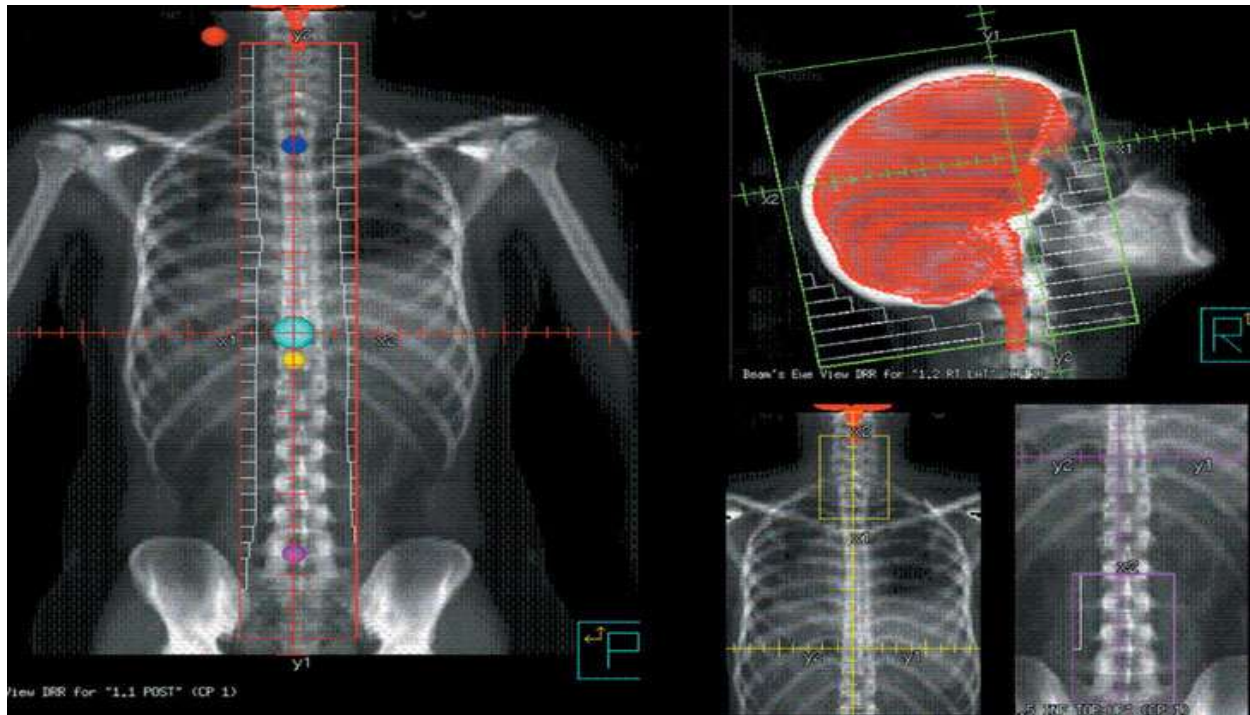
(upper left) image showed the spinal filed margin in 3DCRT, (upper right) image plain radiograph for lateral skull demonstrate the cranial filed borders, and lateral whole body CT reconstruction in the (lower) image demonstrate the filed irradiation in case of CSRT 3DCRT with border separation. (Barrett et.al (2009)).
